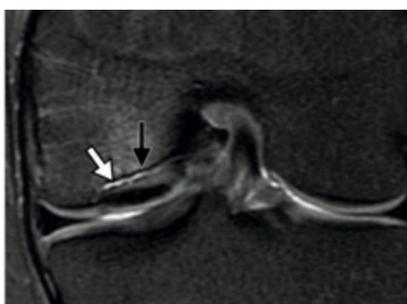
T1-weighted image (left) and fat saturation T2-weighted image (right); osteochondritis dissecans (vertical arrow) and deep edema of epiphyseal bone (horizontal arrow).
